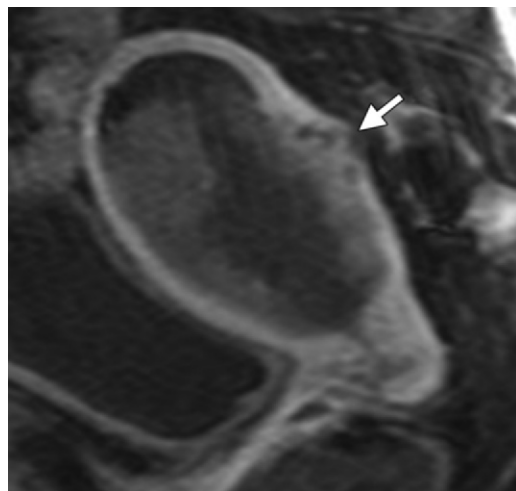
Stage IIIA endometrial carcinoma (grade 3 endometrioid adenocarcinoma) in a 60-year-old woman. Sagittal T1-weighted MR image obtained after intravenous administration of gadolinium-based contrast material shows a bulky endometrial tumor with relatively low signal intensity distending the endometrial cavity and extending through the avidly enhancing myometrium to the serosal surface (arrow).
